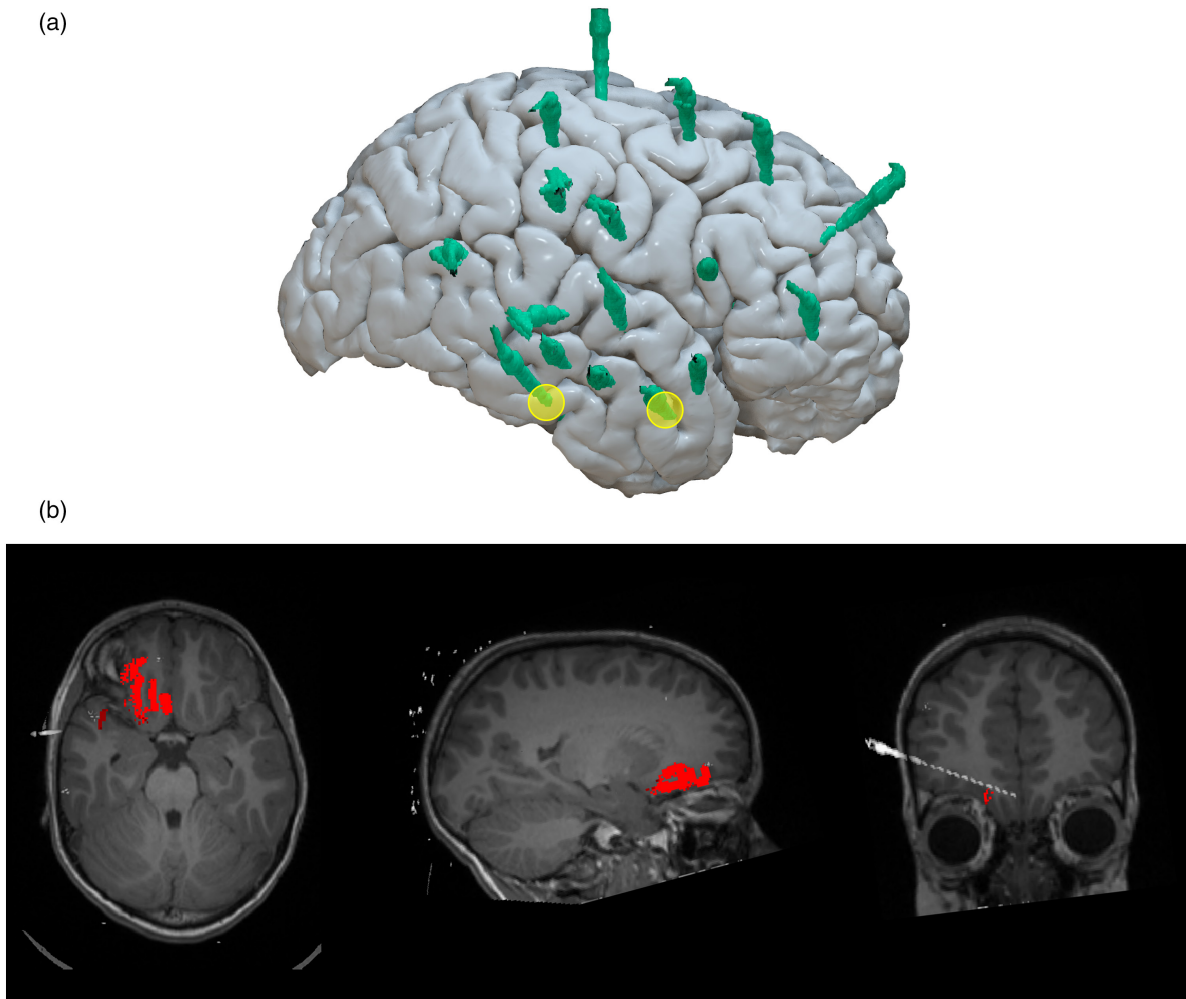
Case study no. 2. (a) 3D view of the cortical surface with the SEEG electrodes shown in green. Yellow identifies the additional electrodes implanted as part of the MAST trial. (b) Axial, sagittal, and coronal views of the T1 magnetic resonance imaging scan with the MAST clusters visible in red. A significant cluster identified in the orbitofrontal cortex did not meet the threshold for being one of the top three clusters but was identified as part of the seizure-onset zone through the electrode show in the coronal image. It was removed as part of subsequent anterior frontal resection. Abbreviations: MAST, MELD as an adjunct for SEEG trajectories; SEEG, stereoelectroencephalography.
